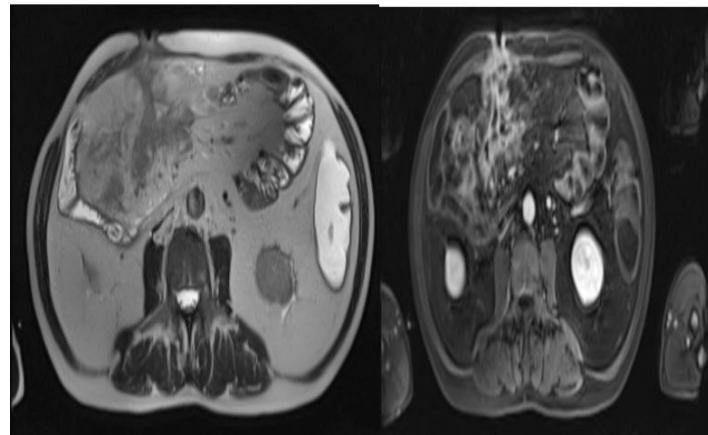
Axial T2-weighted TSE MR sequence (A) demonstrating inhomogeneous mass with irregular margins and peripheral fat stranding in the right abdomen that reaches the anterior right abdominal wall with a trans-muscular fistulous tract; axial T1-weighted VIBE MR sequence (B) after contrast administration showed significant and inhomogeneous contrast enhancement of the mass as well as of the mesenteric fat; of note, the mass is characterized by multiple fluid collections.
